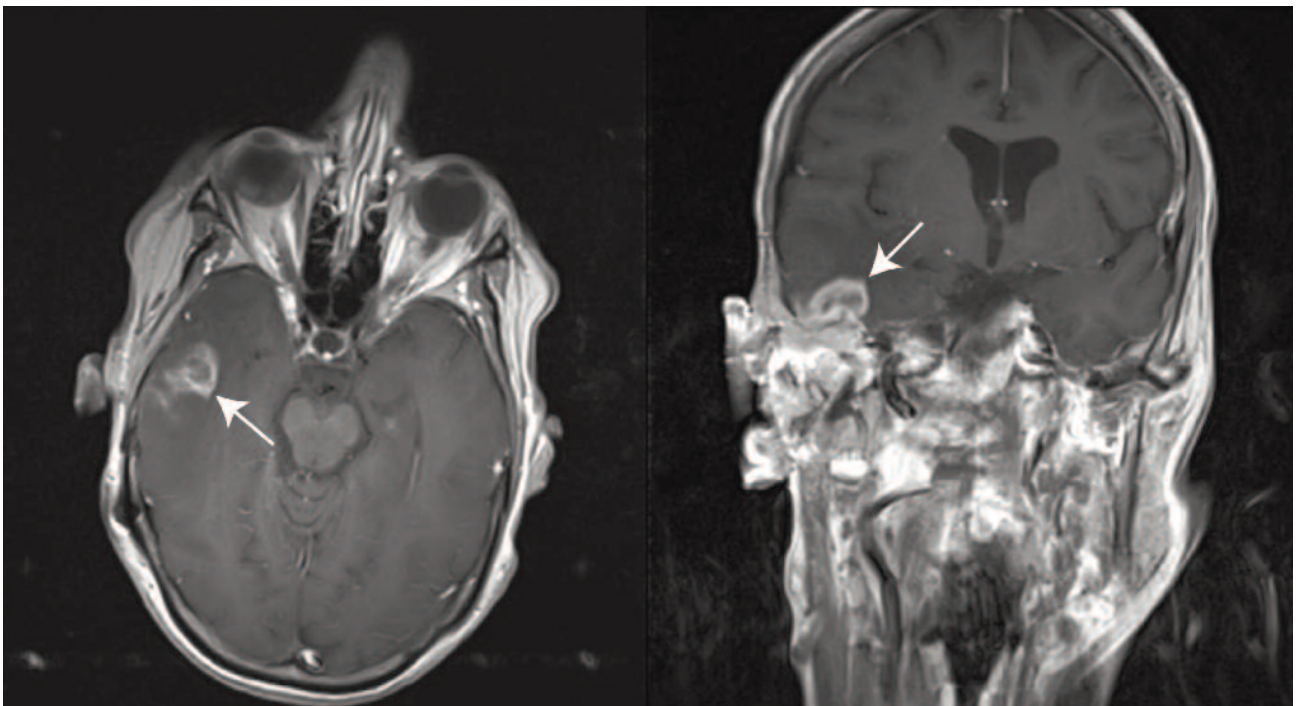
Unchanged MRI scan (T1W + flowcomp, axial and coronal plane) before the neurosurgical intervention and drainage (March 2008). The arrows indicate the presence of an intracranial abscess.
